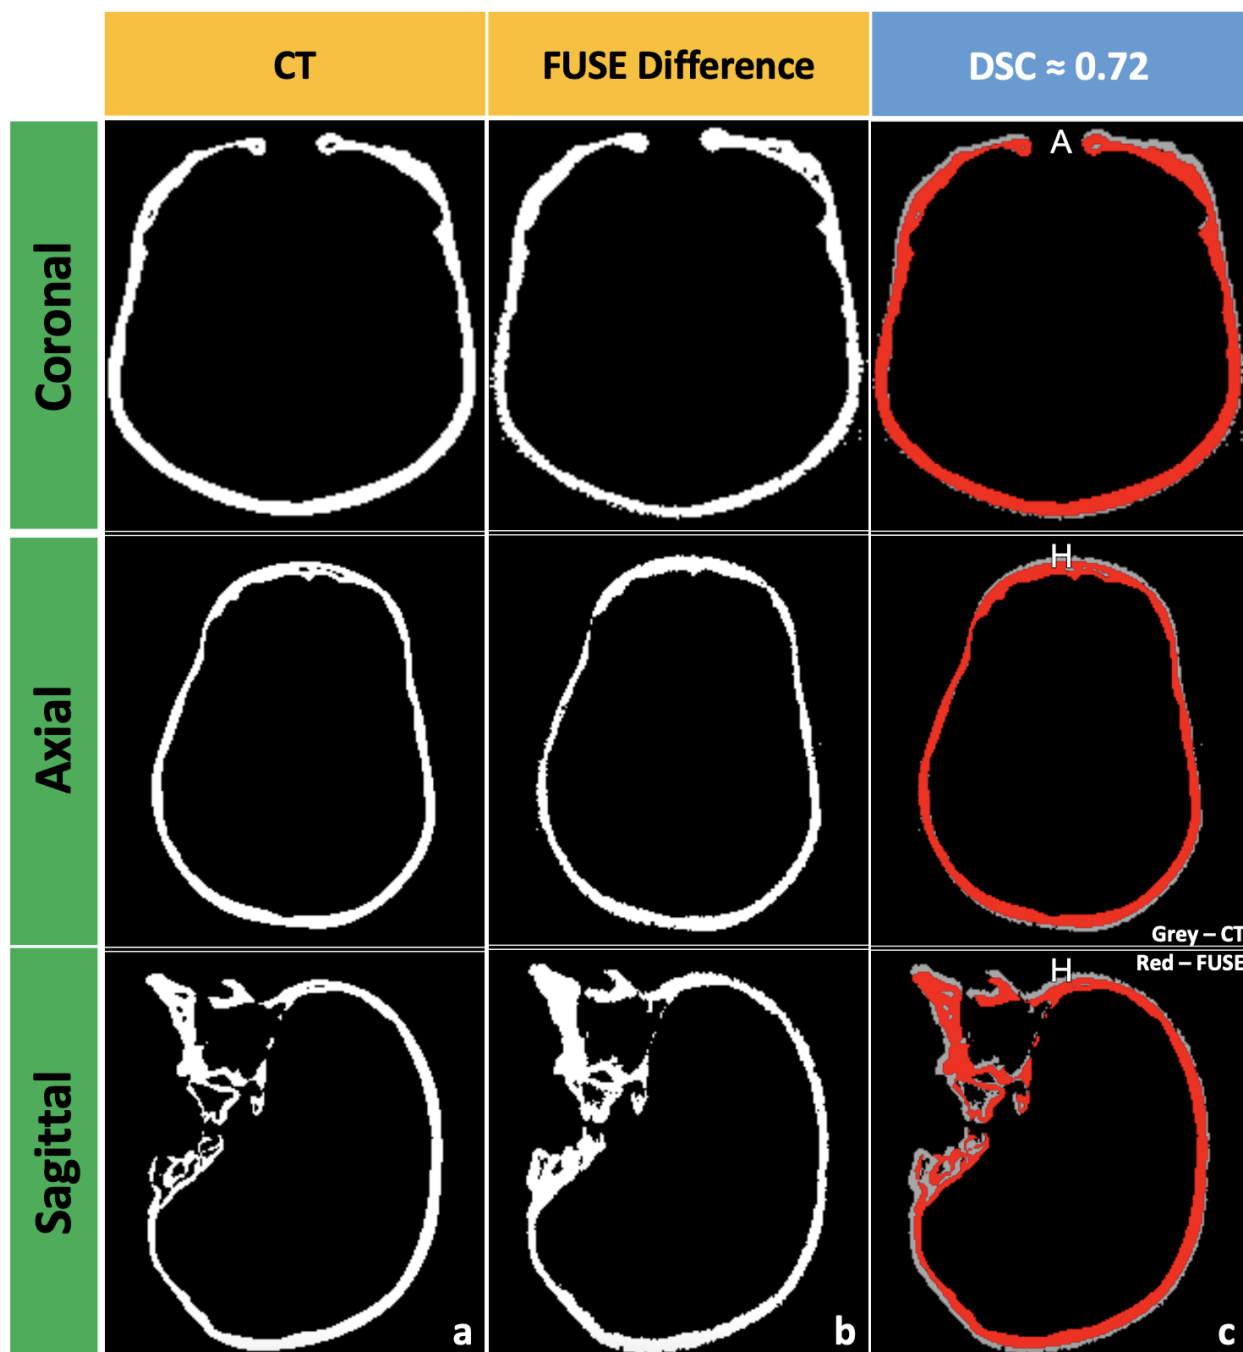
Geometrical evaluation between CT and FUSE.
